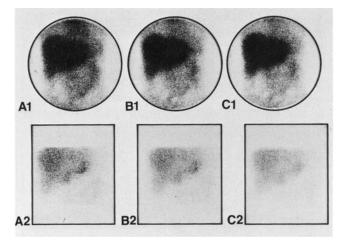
Overlapping of pancreas by liver shadow is observed in scintigrams (A1, B1, C1), as well as in tomographic images (A2, B2, C2).
